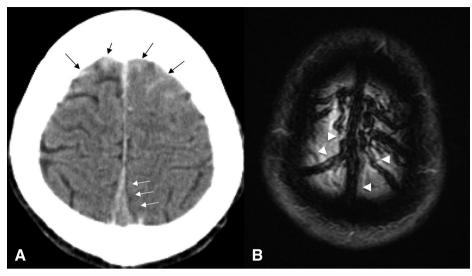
(A) Initial CT shows local subarachnoid hemorrhage in bilateral frontal lobes (black arrows) and dense clot sign in the SSS (white arrows). (B) MRI (T2*WI) reveals susceptibility vessel sign of the SSS and adjacent cortical veins (white arrowheads). SSS: superior sagittal sinus
